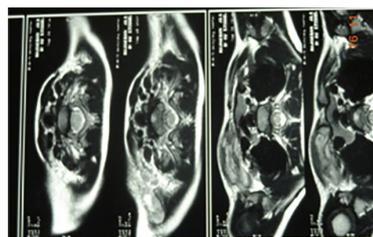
MRI signal changes in right clavicle secondary to acute osteomyelitis
